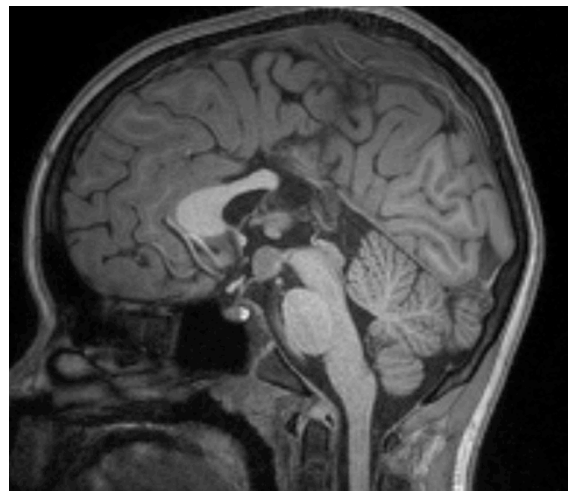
T1-weighted mid-sagittal magnetic resonance imaging showing partial AgCC. Image taken from the AgCC Study of the Murdoch Children's Research Institute.
